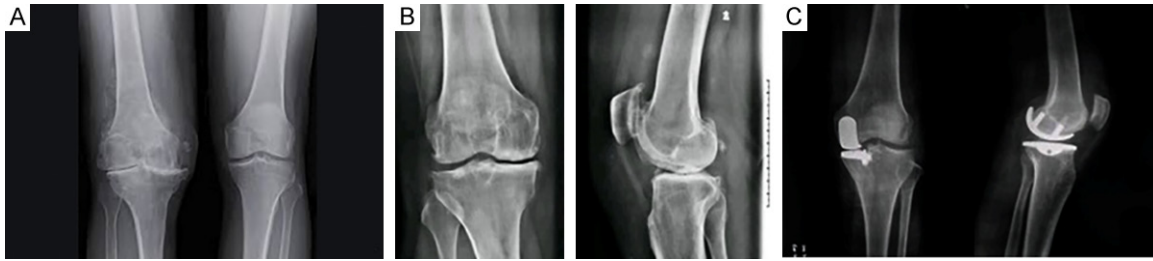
X-ray images of KOA patients. A. KOA in right limb normal knee joint in left limb; B. Normal X-ray; C. KOA in both limbs. KOA: knee osteoarthritis.
